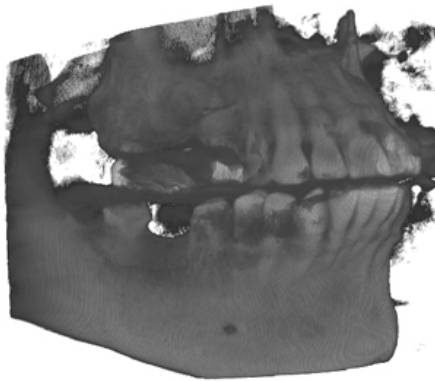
Side view of a raw CBCT volume.
